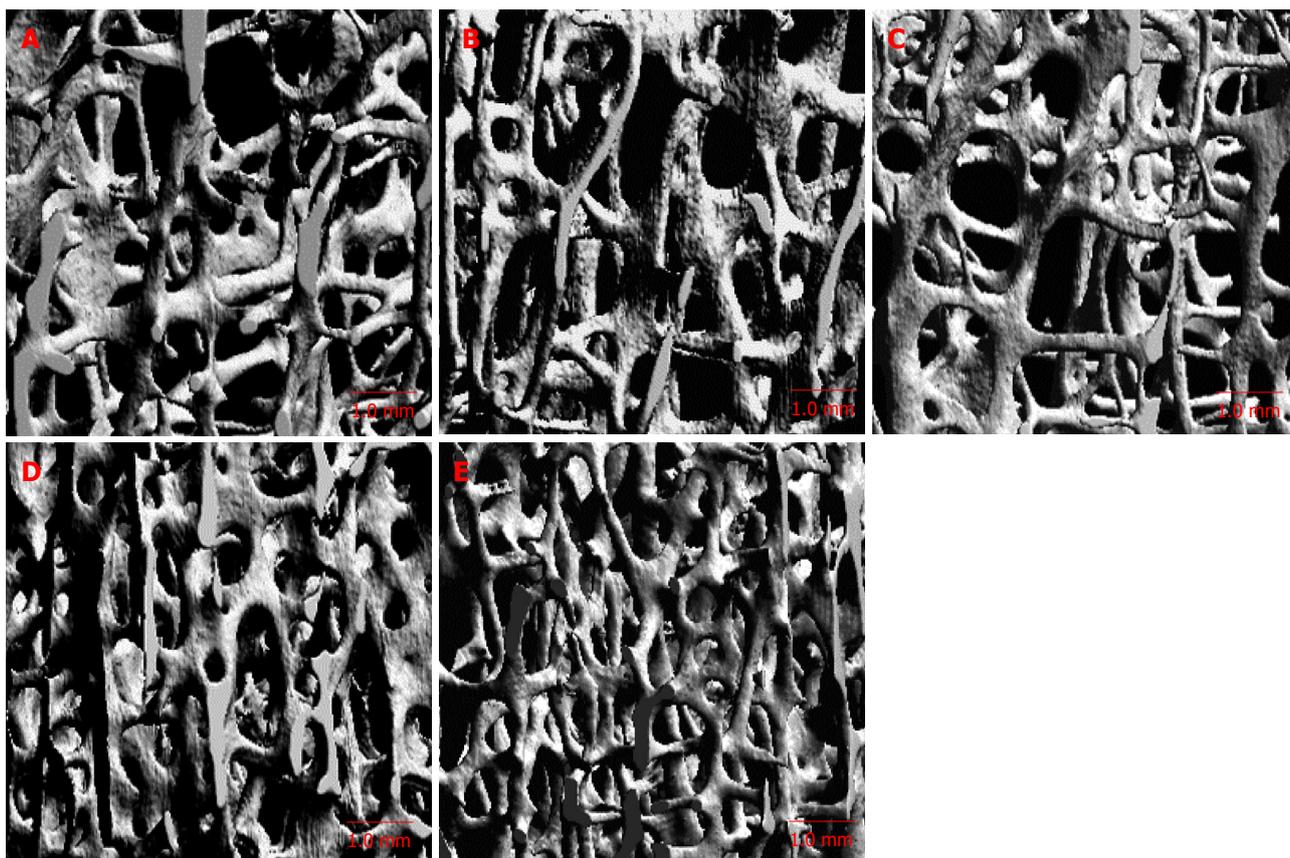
Micro-computed tomography image in different regions of vertebral body^[25]. A: Anterosuperior; B: Anteroinferior; C: Central; D: Posterosuperior; E: Posteroinferior regions. The trabecular bone is lower in the anterosuperior and central regions.
